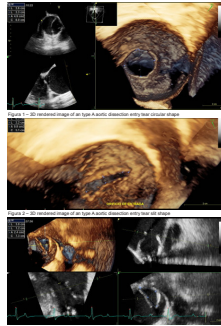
3D Transesophageal Echo of Aortic Dissection showing the Primary Entry Tear
